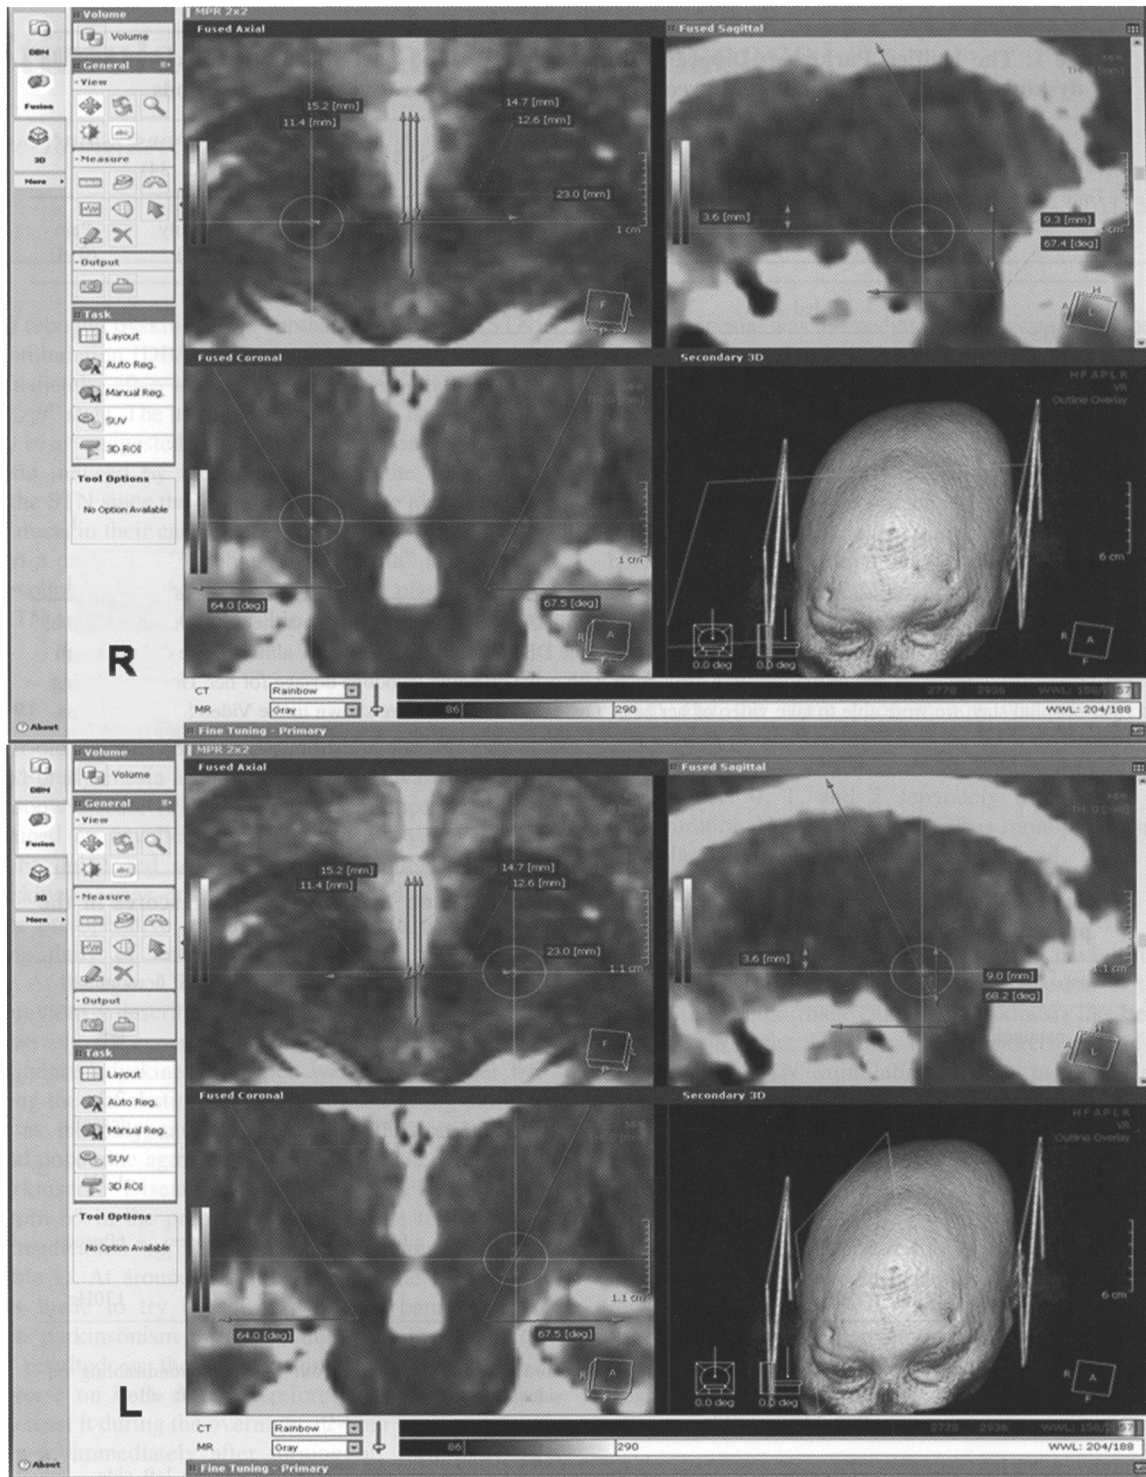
Fusion image of the preoperative magnetic resonance image and the 6-month-postoperative computed tomography scans of the patient using a previously described method.² 'R' designates the electrode on the right side and 'L' designates the left side. The locations of the electrodes for each side are shown in three planes: (1) an axial view at a level of 3.5 mm below the anterior-posterior commissural (AC-PC) line (upper left), (2) a coronal view at a level of 3.0 mm posterior to the mid-commissural point (lower left), and (3) a sagittal view at a level of 12 mm lateral to the midline (upper right). In the axial view, the electrodes were located 11.4 mm (for the right electrode) and 12.6 mm (for the left electrode) from the AC-PC line. In the sagittal view, the depths of the lowest contacts were 9.3 mm (for the right electrode) and 9.0 mm (for the left electrode) from the AC-PC line. Contacts 2 and 3 of both sides were placed inside the STN, but contact 2 was near the ventral border and contact 1 was placed over the ventral border of the STN, and contact 0 was placed below the STN in this patient.
